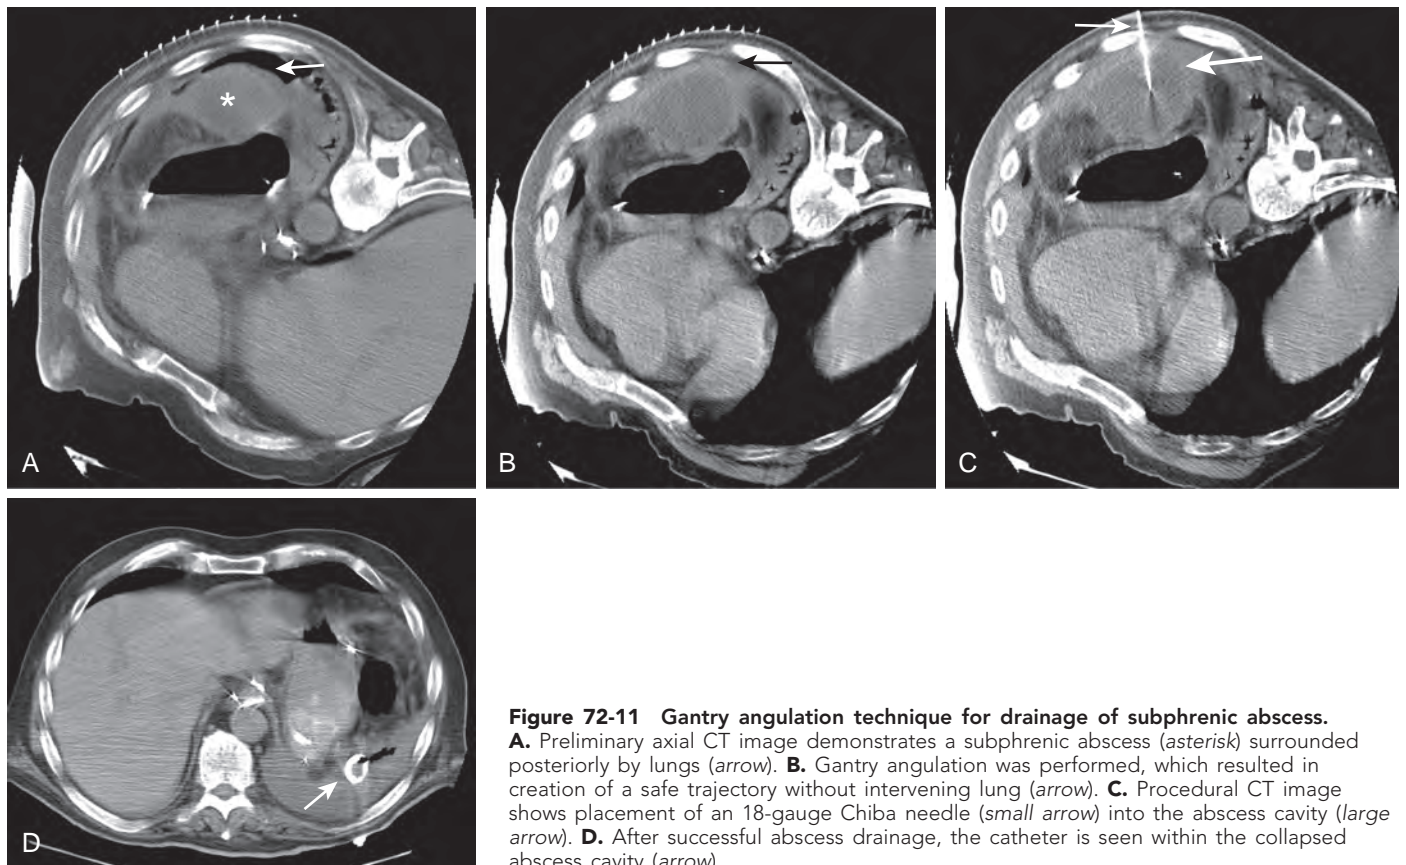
Gantry angulation technique for drainage of subphrenic abscess. A. Preliminary axial CT image demonstrates a subphrenic abscess (*asterisk*) surrounded posteriorly by lungs (*arrow*). B. Gantry angulation was performed, which resulted in creation of a safe trajectory without intervening lung (*arrow*). C. Procedural CT image shows placement of an 18-gauge Chiba needle (*small arrow*) into the abscess cavity (*large arrow*). D. After successful abscess drainage, the catheter is seen within the collapsed abscess cavity (*arrow*).
